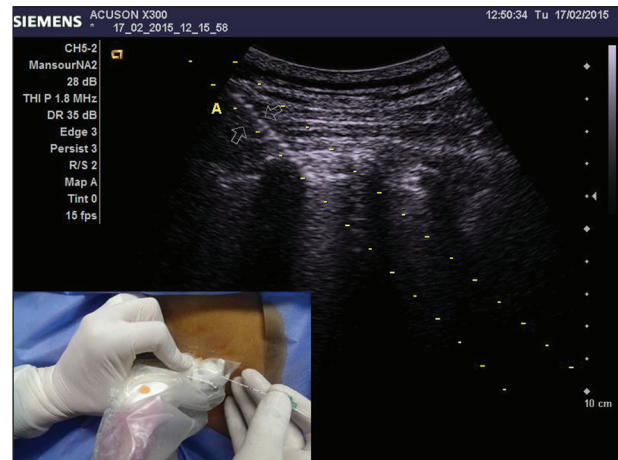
An ultrasound image of a needle approaching the paravertebral space while using the needle guidance system
